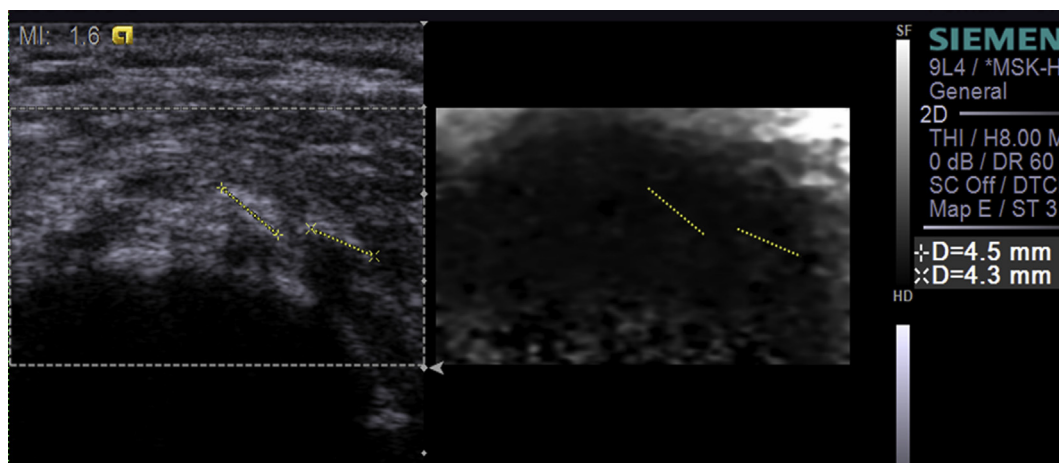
Imaging studies from a 57-year-old woman who complained of severe left shoulder pain for 1 year. Gray-scale ultrasound (US) showed fragmented calcific tendinosis (dotted line), and elastography exhibited a dark pattern (dotted line). The patient received US-guided repeated puncture, and had pain relief.
